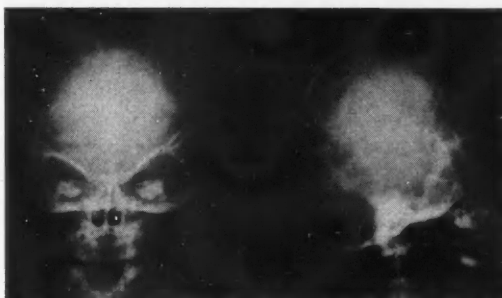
Preoperative roentgenograms of a 5-year-old boy with advanced skull deformity and mental defect associated with premature closure of the coronal suture.
